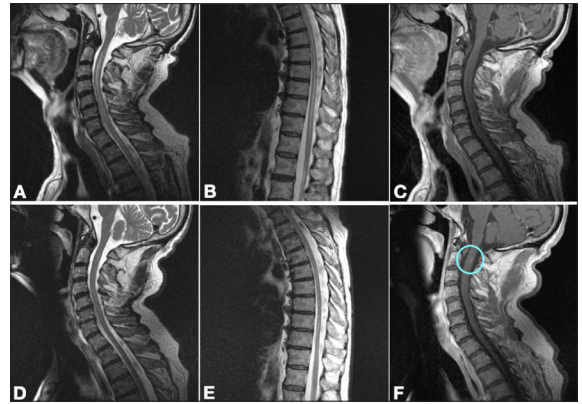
Initial cervical and thoracic MRI showing extensive centromedullary T2 hyperintensity (A, B) with no gadolinium enhancement (C). Follow-up cervical and thoracic MRI showing reduction in lesion size centromedullary T2 hyperintensity (D,E) but with evidence of slight gadolinium enhancement (F)
